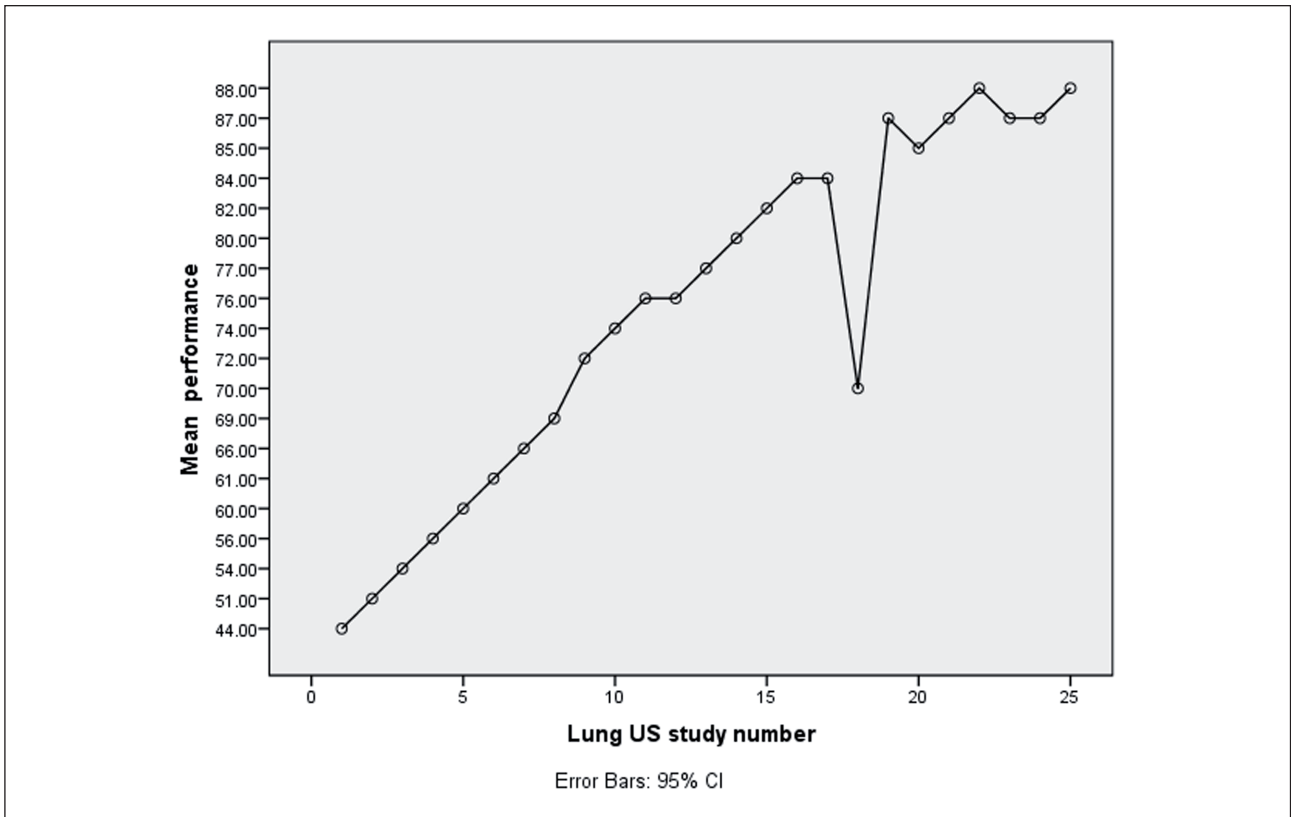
Correlation curve of fellows’ performance in lung ultrasound (LUS), horizontal axis represents order number of studies, and vertical axis represents mean of performance mark.
